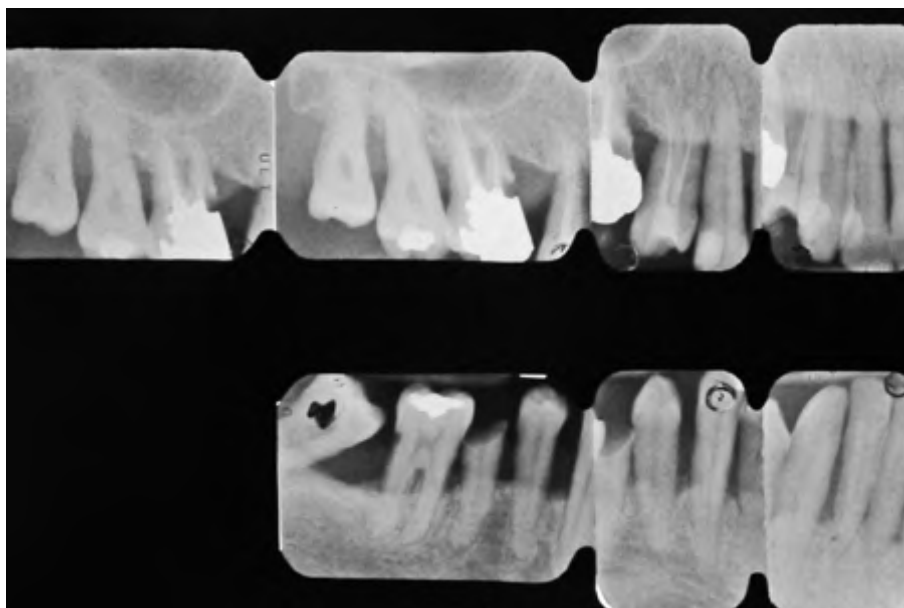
Preoperative periapical radiographs of the right posterior quadrants.
